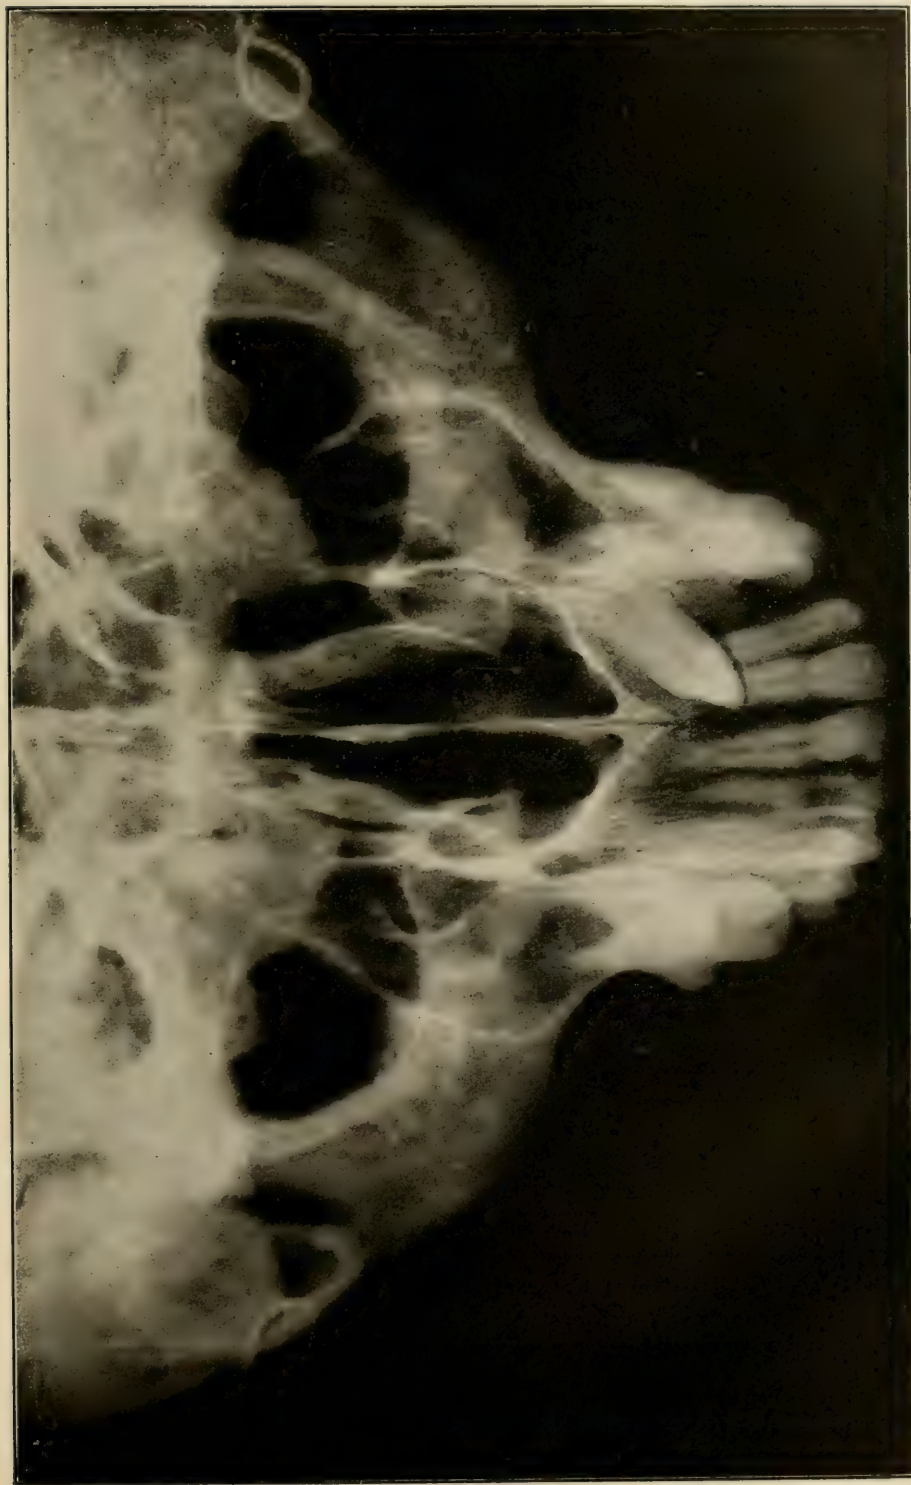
The same as Fig. 124, except that the half-tone was made directly from the glass negative instead of from a photographic print. This radiograph is of a dry skull. (Radiograph by C. r. v. r.)
